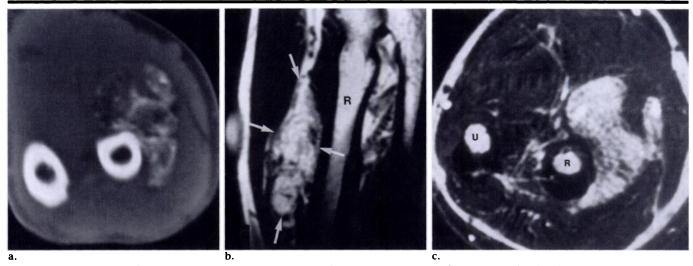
Periostitis ossificans (juxtacortical). (a) CT image reveals extensive, mature ossification immediately adjacent to the cortex of the radius. (b) Sagittal T1-weighted MR image through the radius (SE 600/18). R = radius, arrows surround mass. (c) Axial T2-weighted MR image (SE 2,400/80). The combination of the T1- and T2-weighted image shows that the lesion contains a large amount of fat but fails to reveal the mature ossification, the key to the diagnosis. R = radius, U = ulna.
